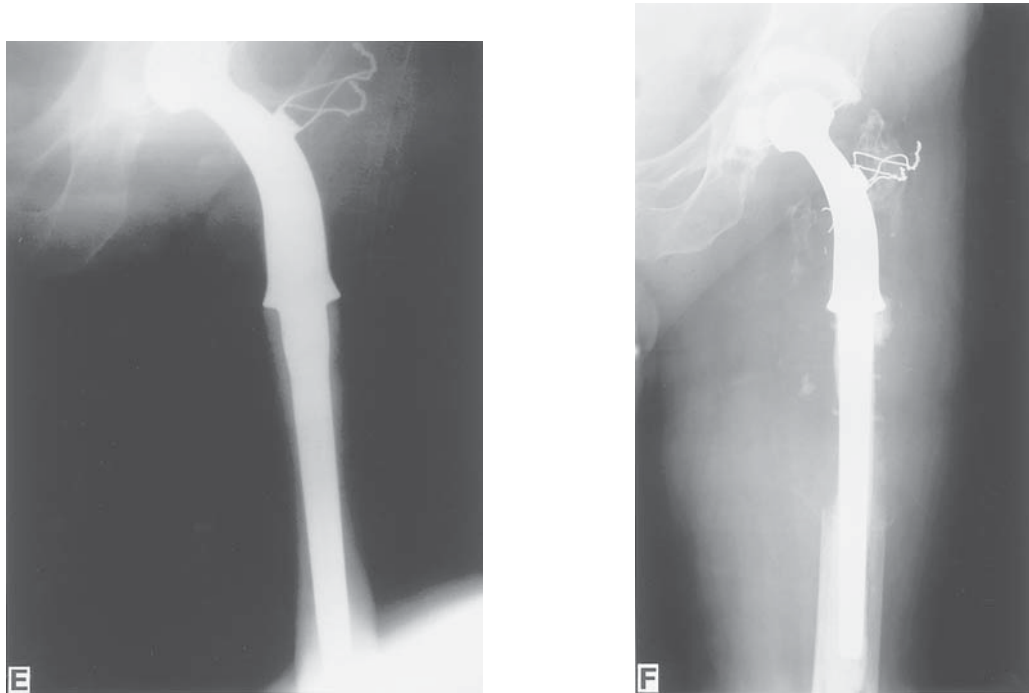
(Continued). (E) Early postoperative film with restoration of femur by a proximal femoral replacement with a total hip acetabular cup because the nail destroyed acetabular articular cartilage. (F) Radiograph 30 mo later with patient fully ambulatory with use of a cane. He died three years after en bloc resection and reconstruction. Bone destruction around the cemented stem is evident, but the component remained fixed to bone.
